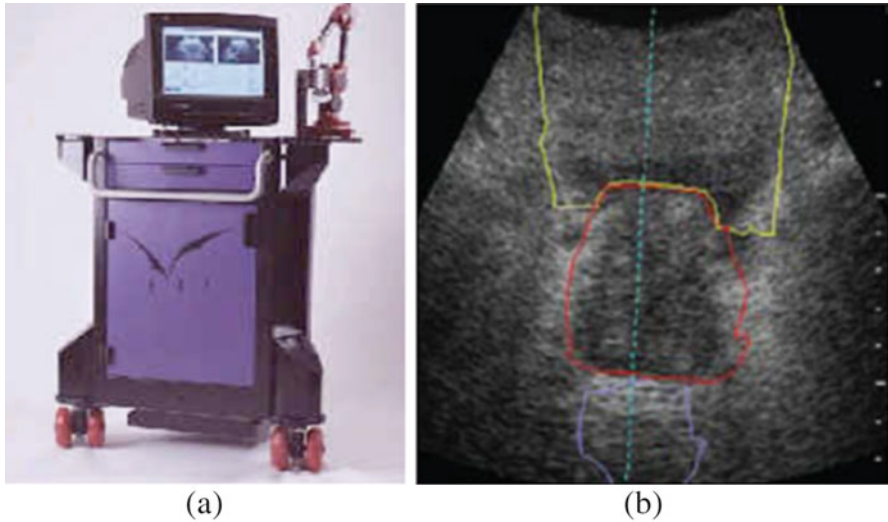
(a) A BAT SXi Ultrasound unit from MONOS; (b) An Axial ultrasound image with contours overlaid (http://www.nomos.com/pdf/batcam_bro_03.pdf)
